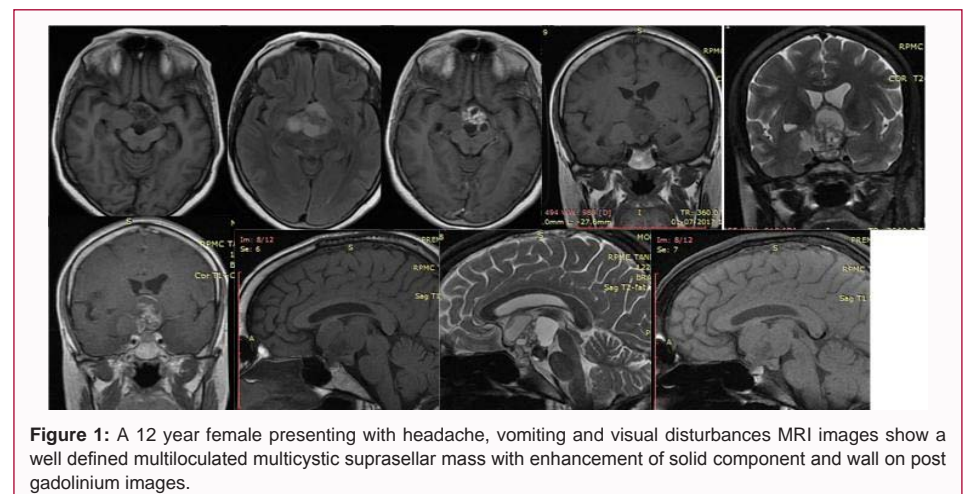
A 12 year female presenting with headache, vomiting and visual disturbances MRI images show a well defined multiloculated multicystic suprasellar mass with enhancement of solid component and wall on post gadolinium images.
